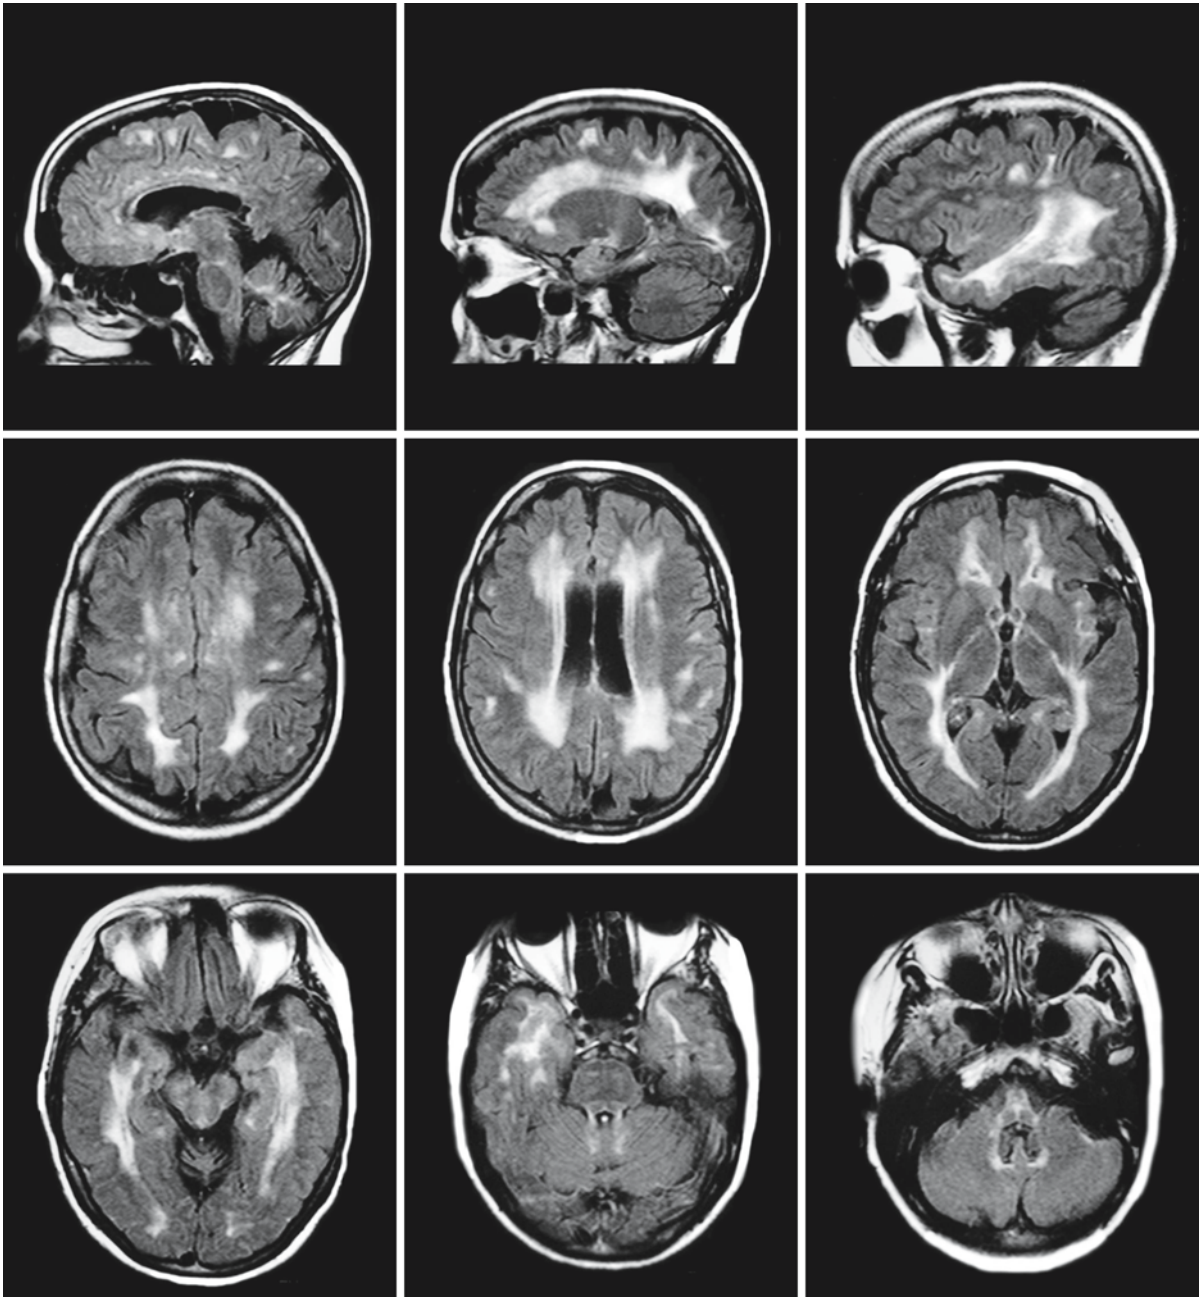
FLAIR images in the 49-year-old sister of the patient in Fig. 16.1. Her disease is radiologically more advanced. There are confluent signal abnormalities in the periventricular white matter with some additional focal spots. The U fibers are relatively preserved. The corpus callosum has become thin. The
